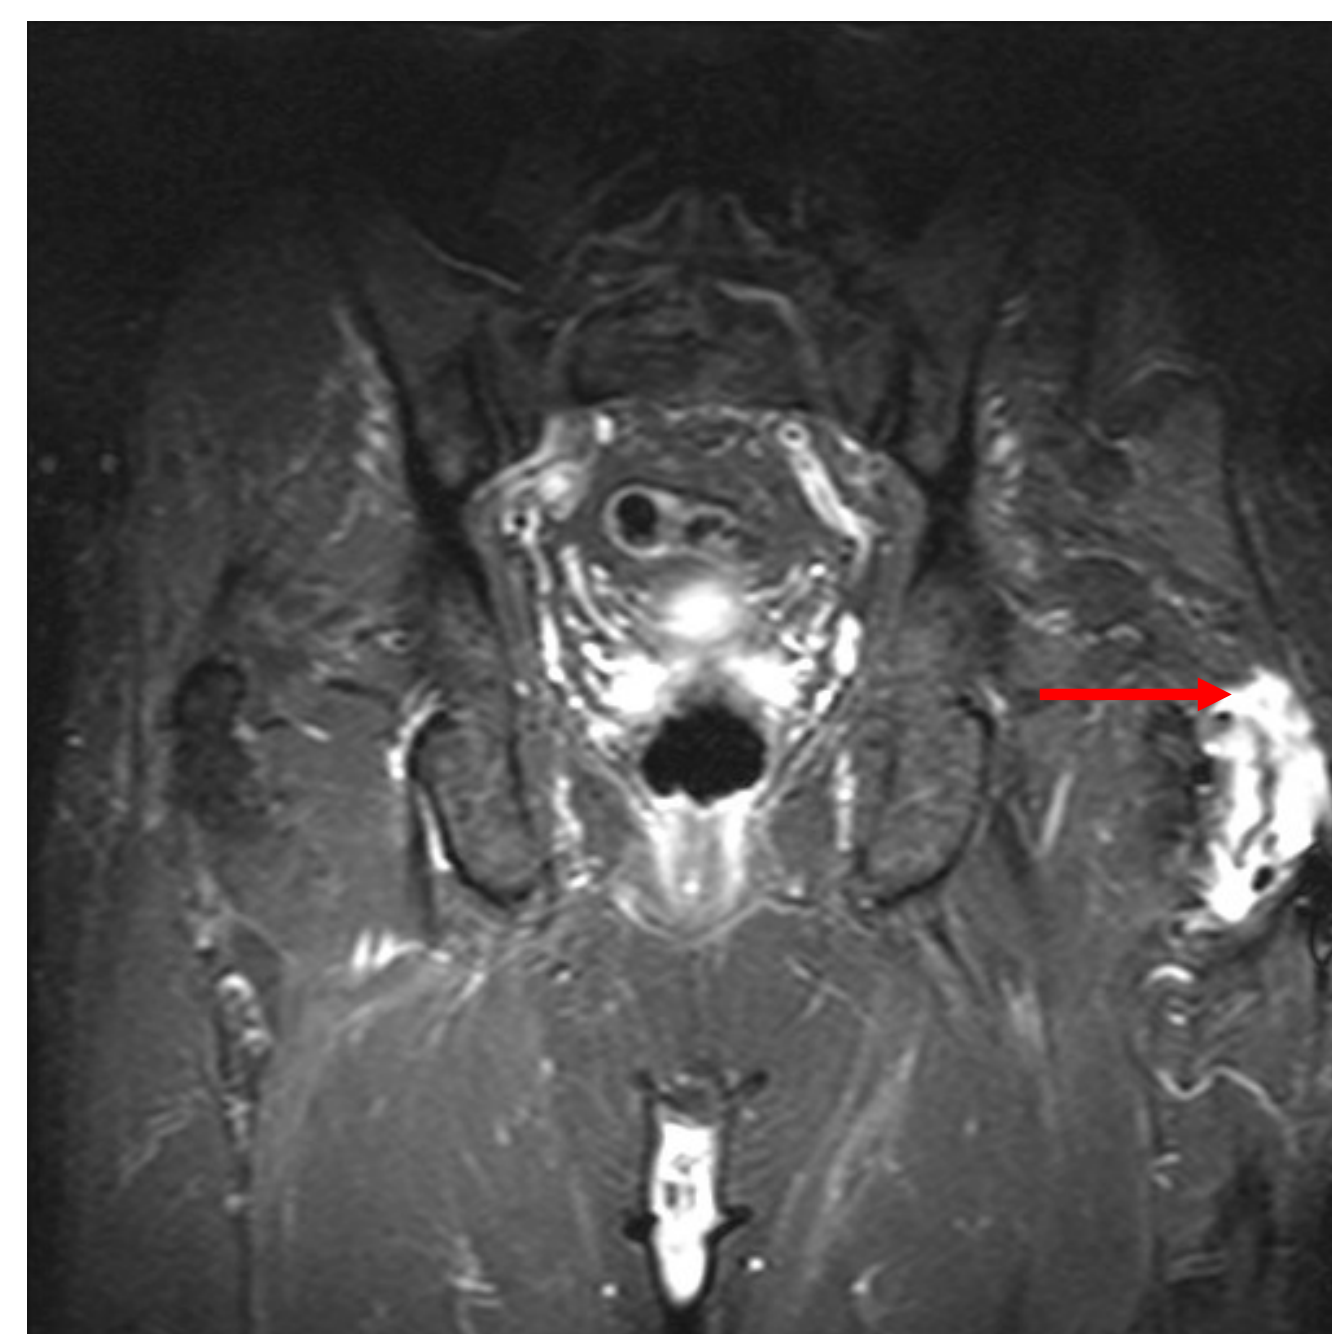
MRI demonstrating gluteus medius tear for patient in Case One.
